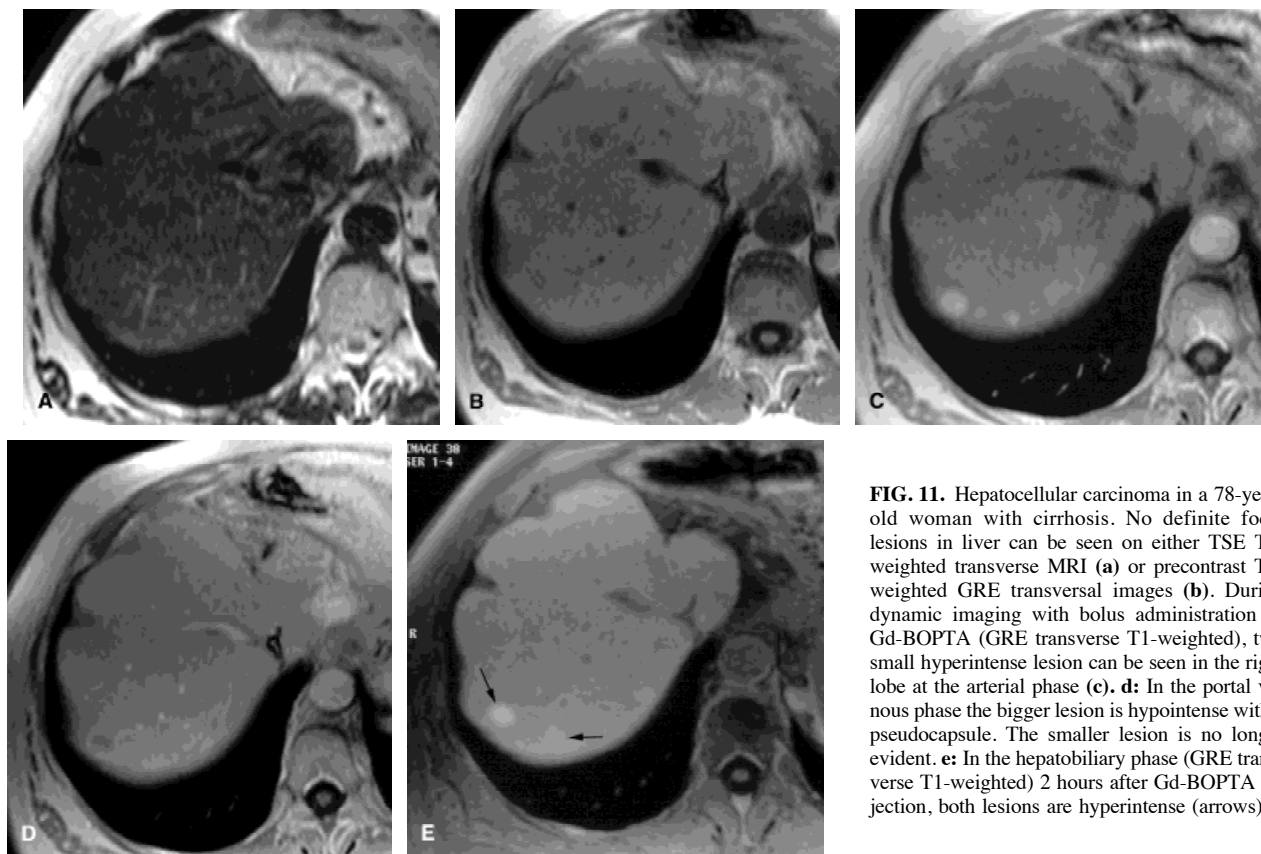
Hepatocellular carcinoma in a 78-year-old woman with cirrhosis. No definite focal lesions in liver can be seen on either TSE T2-weighted transverse MRI (a) or precontrast T1-weighted GRE transversal images (b). During dynamic imaging with bolus administration of Gd-BOPTA (GRE transverse T1-weighted), two small hyperintense lesion can be seen in the right lobe at the arterial phase (c). d: In the portal venous phase the bigger lesion is hypointense with a pseudocapsule. The smaller lesion is no longer evident. e: In the hepatobiliary phase (GRE transverse T1-weighted) 2 hours after Gd-BOPTA injection, both lesions are hyperintense (arrows)
